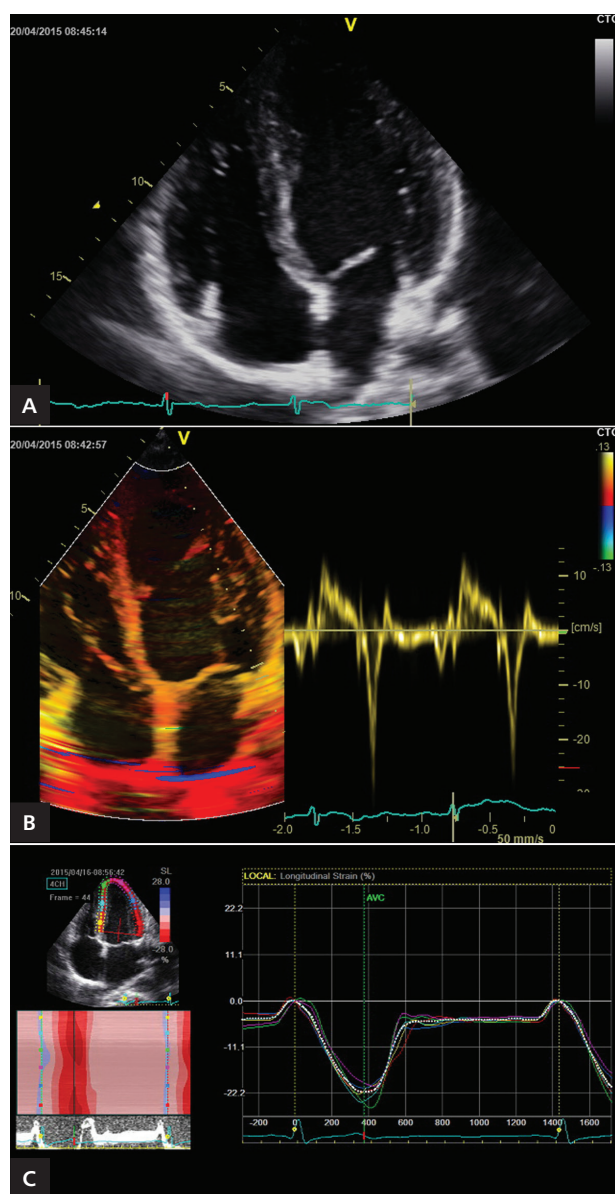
Echocardiography in apical four-chamber views; A. Cardiac chamber imaging using conventional two-dimensional echocardiography; B. Measurement of lateral mitral annulus velocity using tissue Doppler imaging; C. Measurement of left ventricular strain using acoustic speckle tracking
